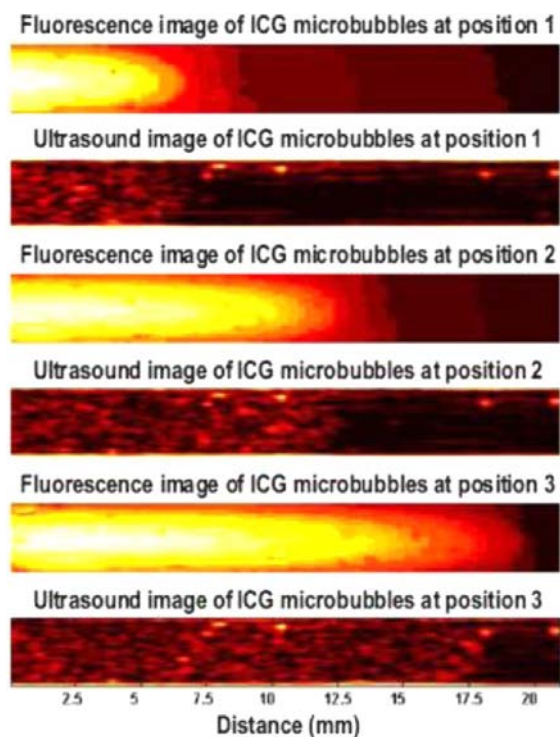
Typical ultrasound and fluorescence images of ICG-encapsulated MBs injected in a transparent tube. Reprinted with permission from ref 37.
